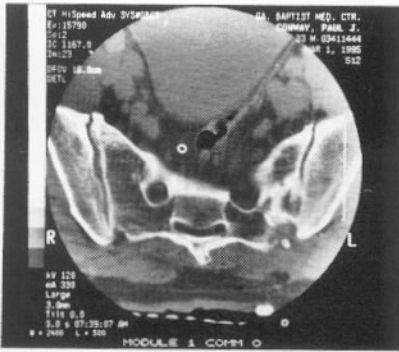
CT scan showing bone graft in SIJ.
